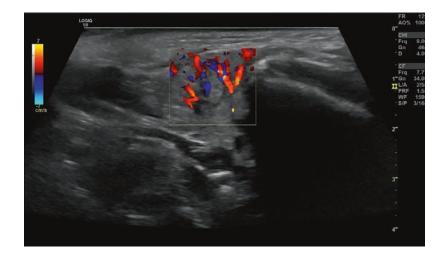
Intraparotid abscess. The inflammation is more diffused and the vascularity of the lesion is very high with the use of color Doppler
